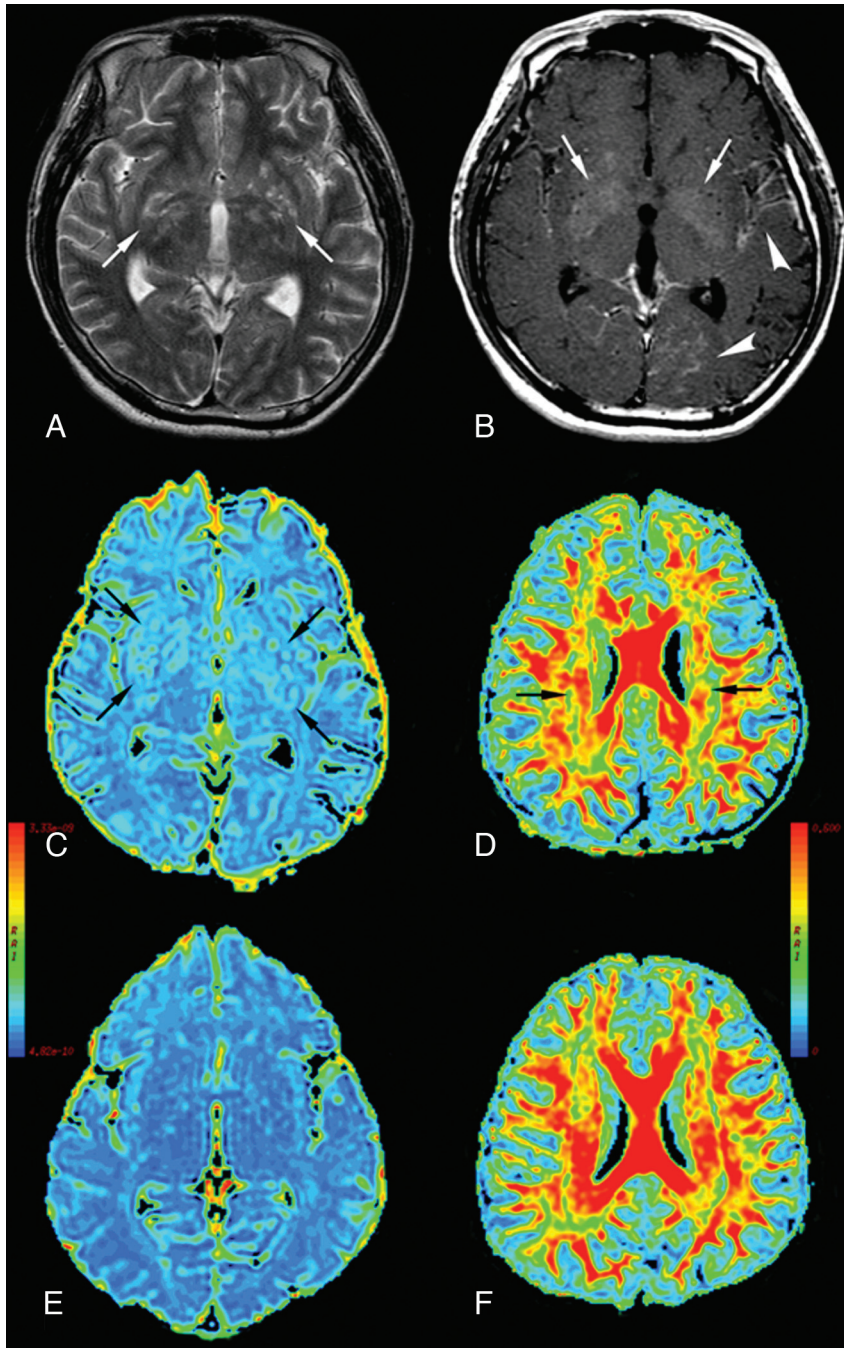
A 31-year-old man with CM (A–D) and a healthy control (E and F). A, Axial T2-weighted image. B, Axial T1-weighted image with contrast infusion displaying bilateral lentiform nucleus (arrows), left temporal and left occipital meningeal enhancement (arrowheads). C, ADC maps displaying bilateral dilated Virchow-Robin spaces (arrows) in the lentiform nucleus, and global cerebral ADC value increased. D, periventricular white matter FA value decreased (arrows).
